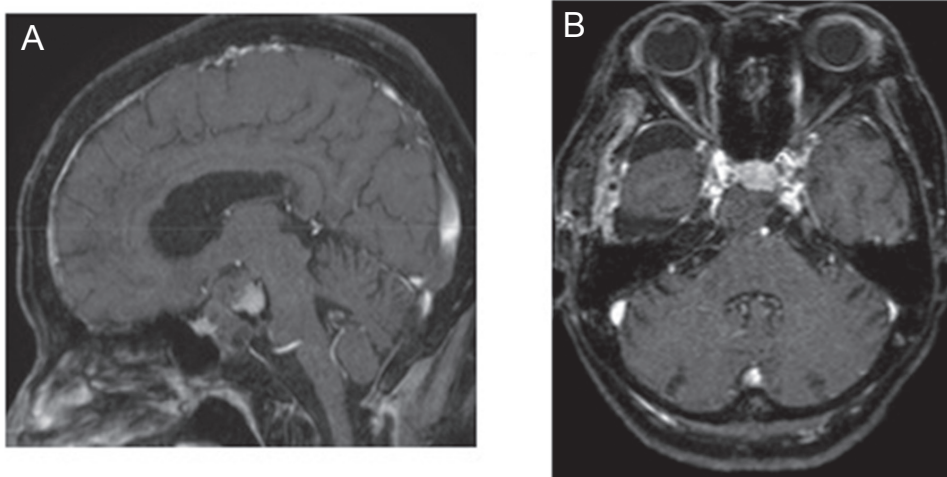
A, B: Postoperative T₁-weighted sagittal (A) and axial (B) magnetic resonance imaging (MRI) with gadolinium reveal no enhanced mass lesion. The intracranial tumor was subtotally removed.
